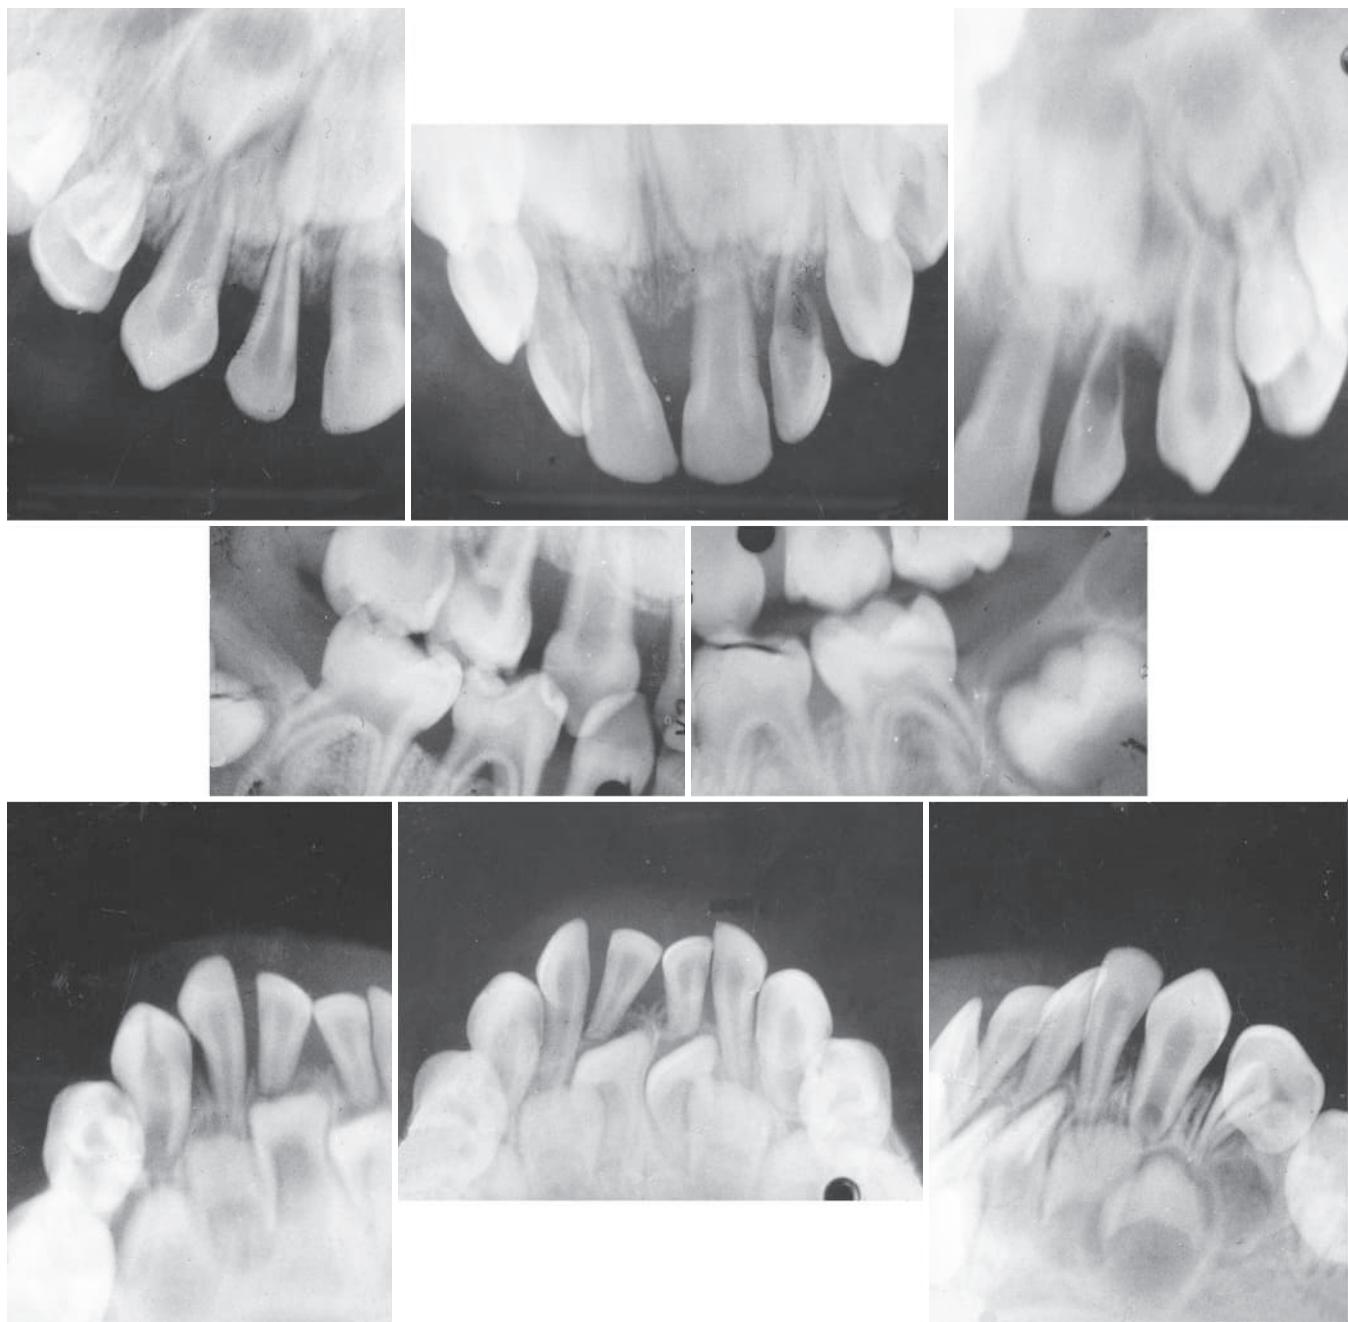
Full-mouth and bitewing radiographs of a 2½-year-old child with Papillon-Lefèvre syndrome. Severe horizontal bone resorption is readily detected in all four quadrants. The incisor areas display extreme alveolar bone loss to the extent that only the apical third of the root remains supported. All primary teeth were extracted by 3 years of age, and dentures were constructed.
